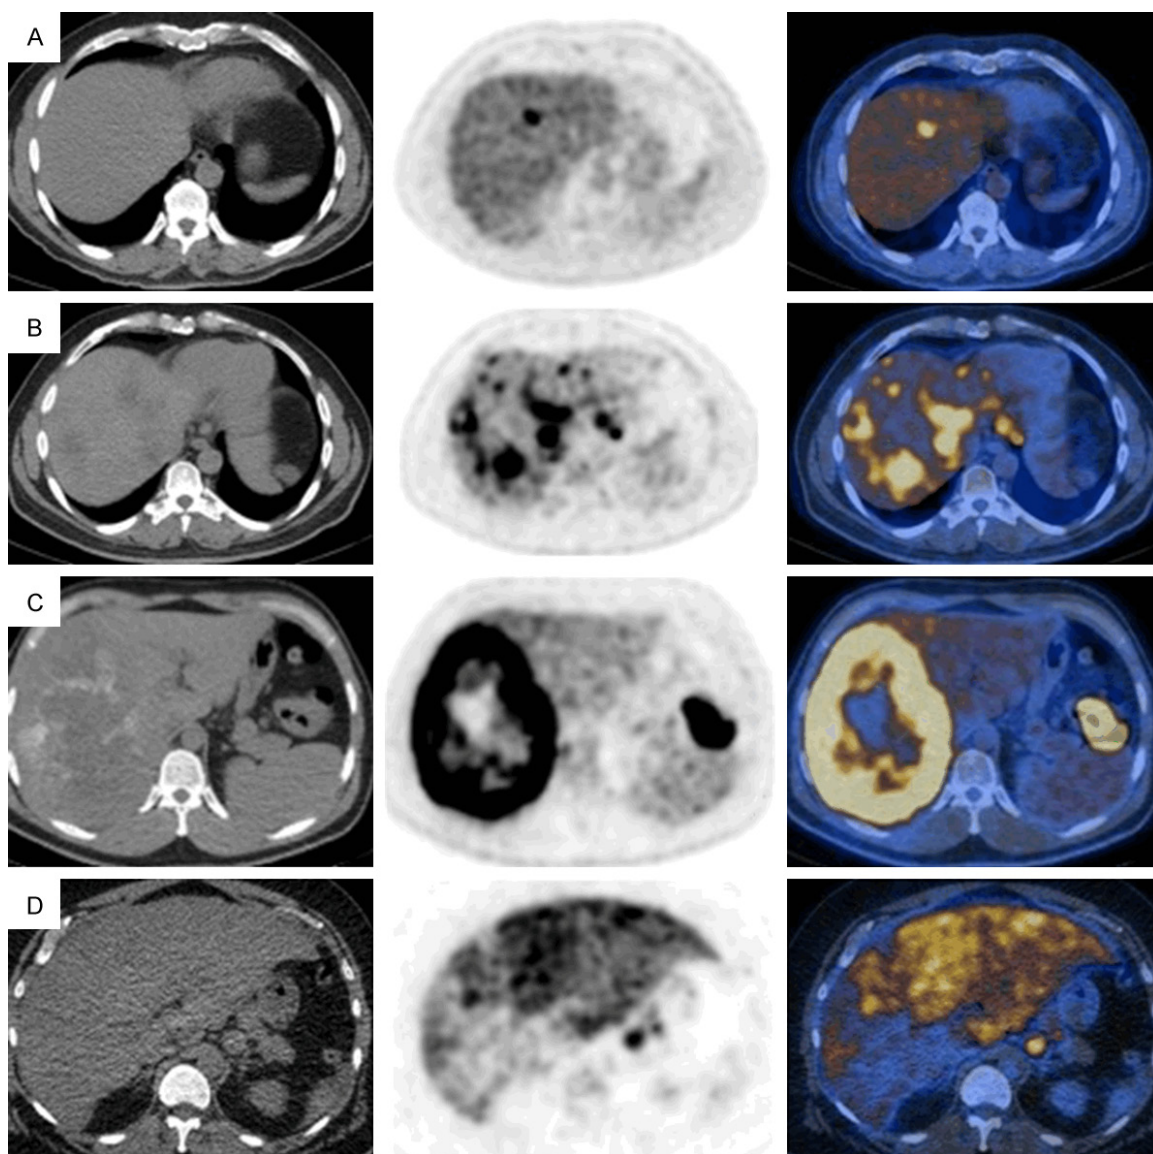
FDG PET/CT images of liver metastases from various tumors (selected transaxial CT, PET and PET/CT fusion images of the liver). Liver metastases from colorectal cancer (A-C): Focal increased uptake in the liver (SUVmax: 7.9) (A), multifocal uptake in both lobes of the liver (SUVmax 8.6) (B) and a large centrally photopenic, peripherally hypermetabolic mass occupying the right hepatic lobe (SUVmax: 19.1) (primary tumor is seen in the splenic flexure) (C). Diffusely and heterogeneously increased uptake in the liver in a case with liver metastasis from gastric cancer (SUVmax 19.2) (D). Focal uptake is seen in a part of gastric tumor at gastroesophageal junction.
